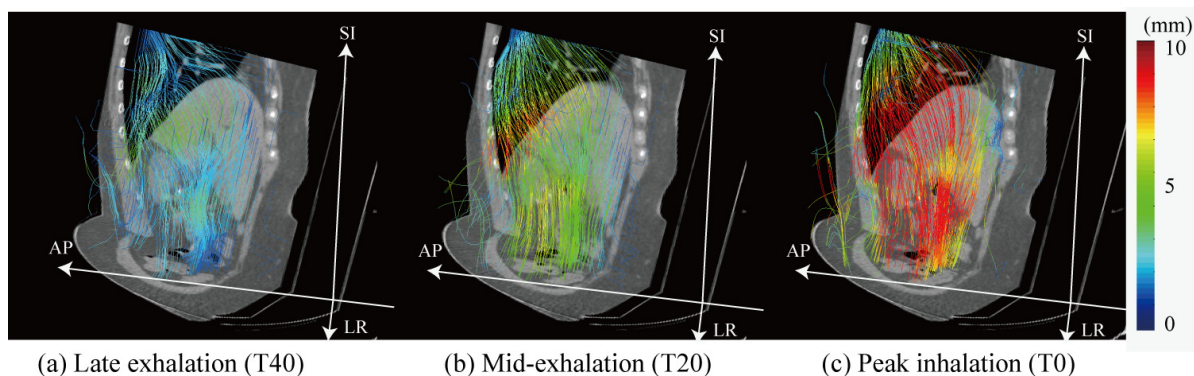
Intrafractional motion curves overlaid on the CT images in oblique view. These curves represent the magnitude of displacement and motion direction from peak exhalation (T50) to respective phases (Tn).
